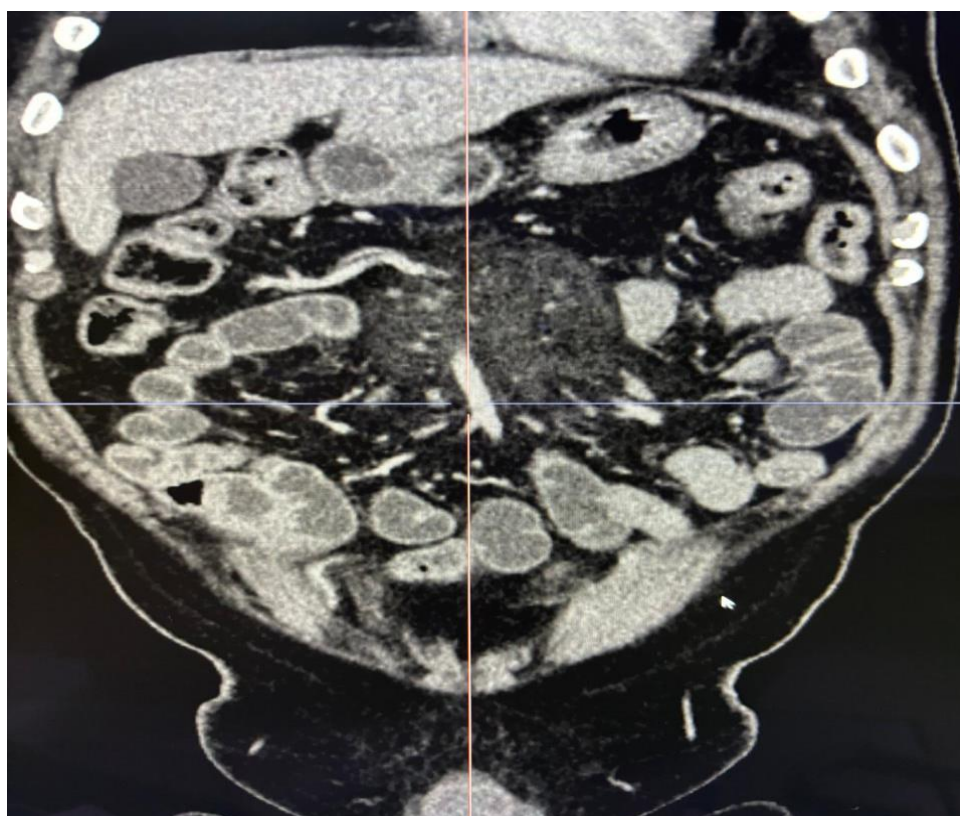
Figure B-Coronal CT scan
